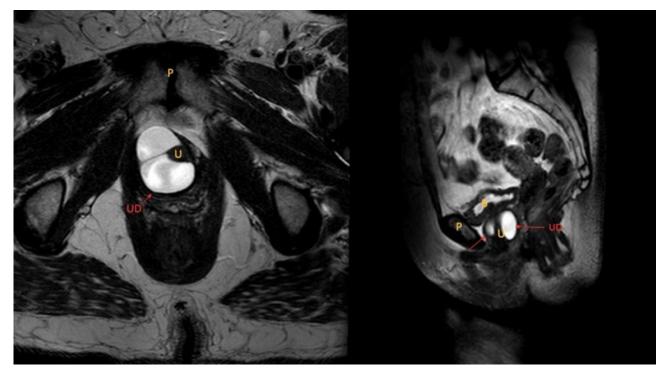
Urethral diverticulum with septation on T2-weighted contrast enhanced MRI. U, urethra. B, bladder. P, pubic bone.
